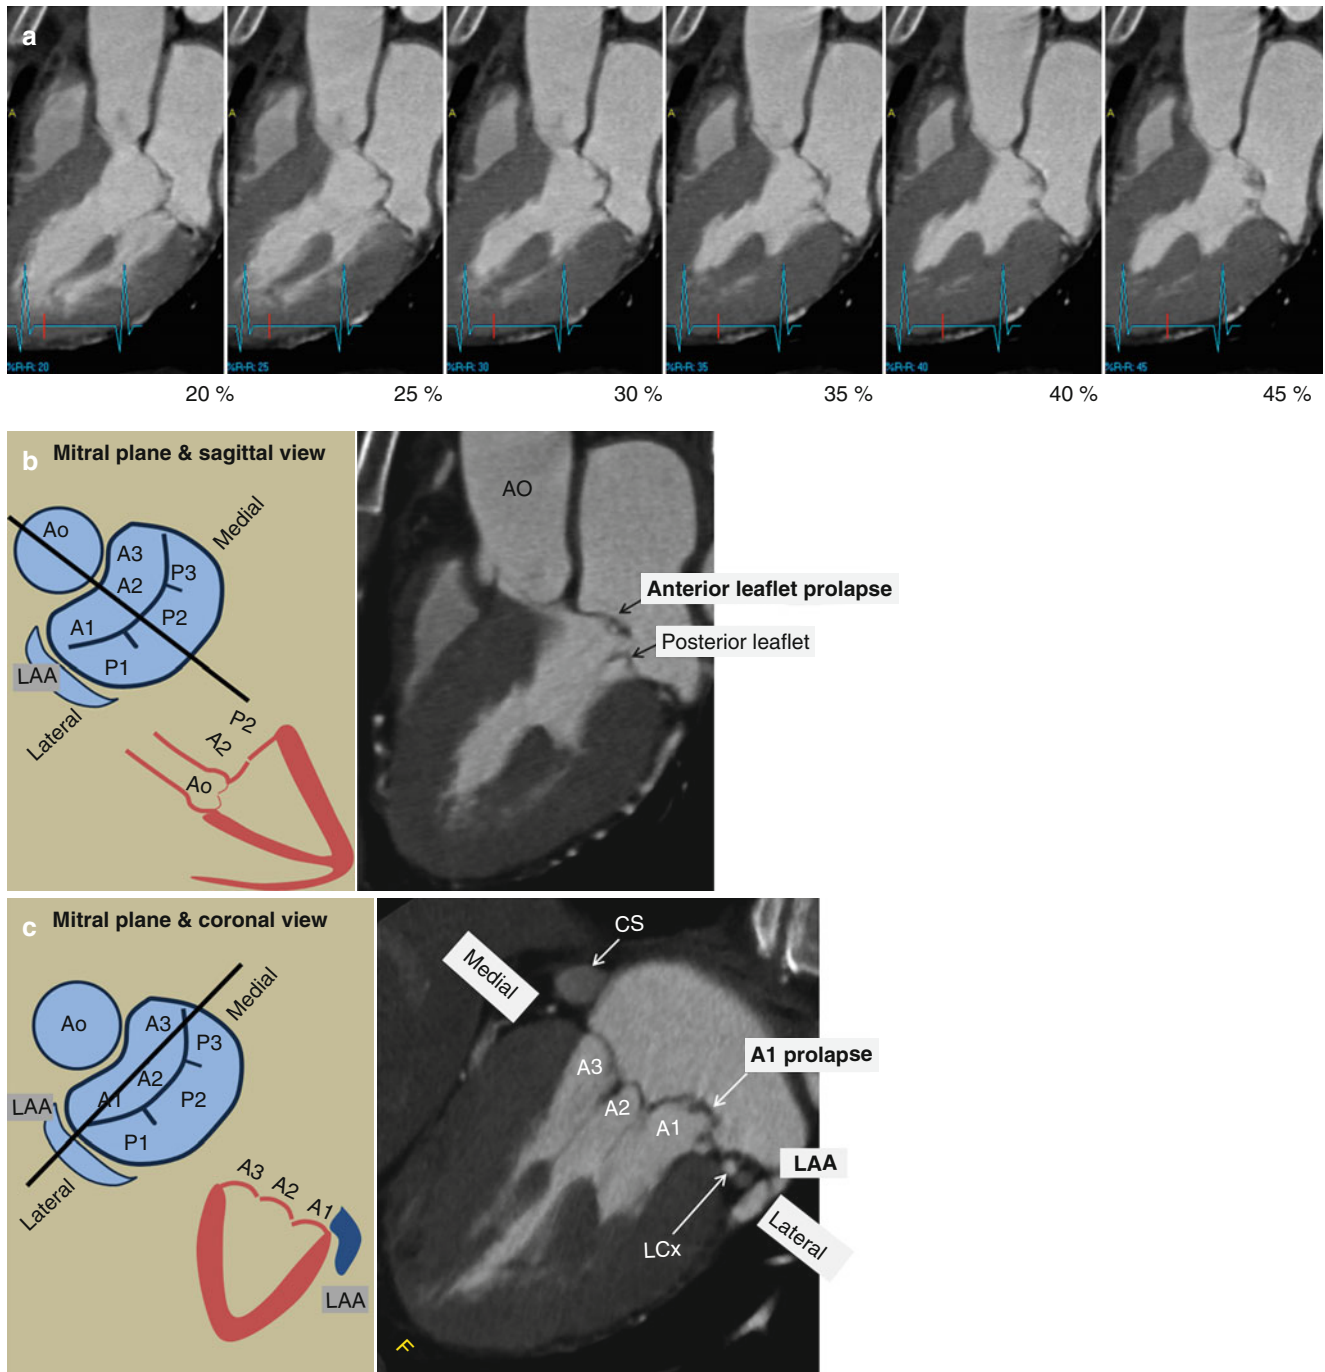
Demonstration of mitral valve prolapse using cardiac CT: 4 steps. (a) Step 1: selection of best cardiac phase. In this patient, 25 % of R-R interval was selected for three-dimensional reconstruction. (b) Step 2: reconstruction of sagittal reformatted image along mitral annular plane. In this image plane, prolapse of the anterior versus posterior leaflet of the mitral valve was determined. AO ascending aorta, LAA left atrial auricle. (c) Step 3: reconstruction of coronal reformatted image
